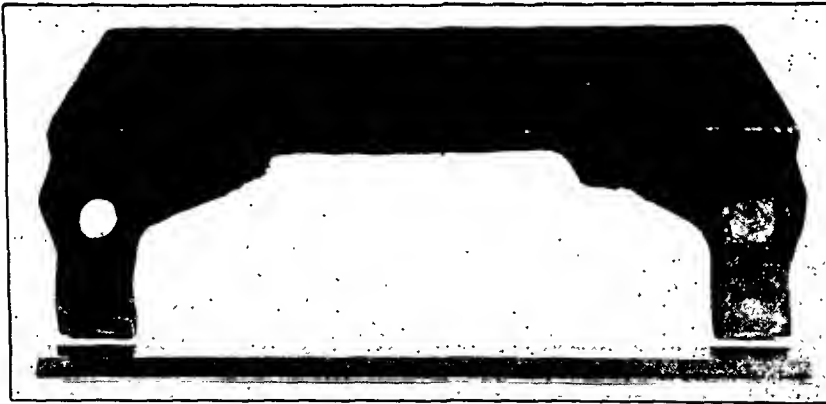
Photograph of steel casting of which radiographs are shown in Figures 14 and 15.
